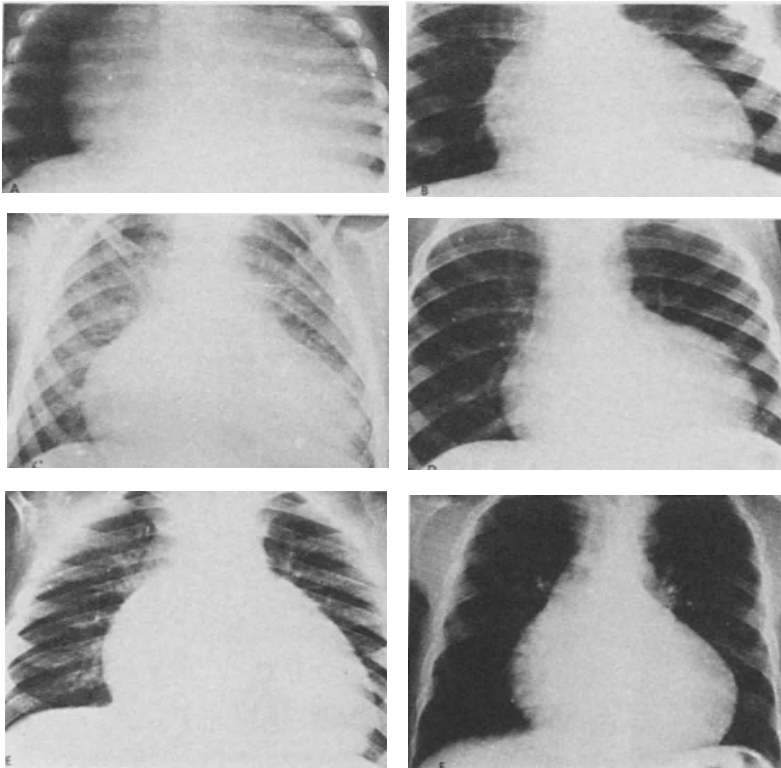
X-rays of the chest in Tetralogy of Fallot complicated by cardiomyopathy (see text).
